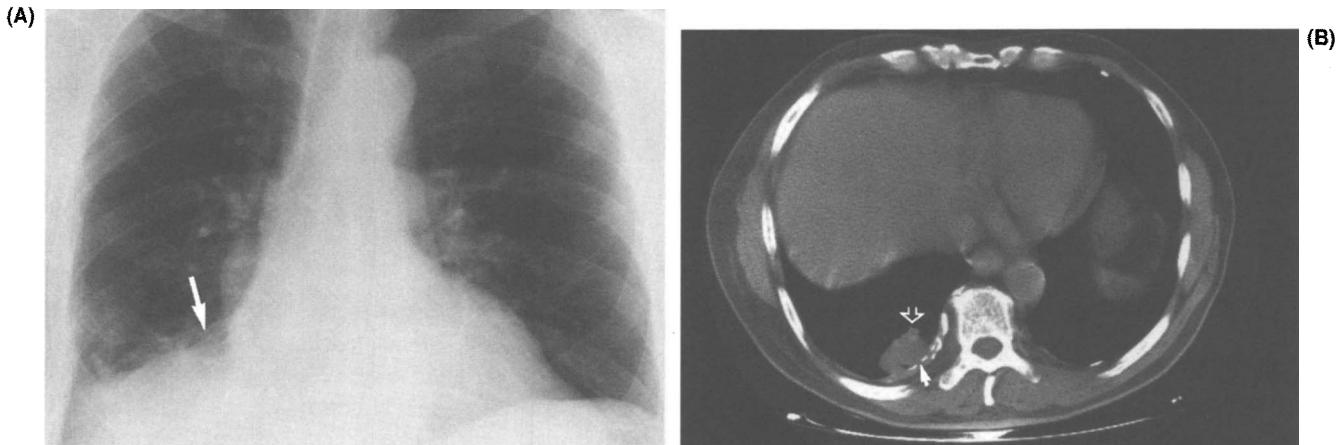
(A) The chest x-ray film reveals an indistinct lesion involving the right lower lobe (solid white arrow). (B) A computed tomographic cut through the lesion reveals a thickened, calcified pleural plaque with extension and engulfment of surrounding lung parenchyma (solid white arrow). There is also with a "comet tail" sign (open white arrow) resulting from involvement of the bronchovascular bundle. The lesion was noted to be stable for 3 years. These findings are consistent with rounded atelectasis due to asbestos exposure.
